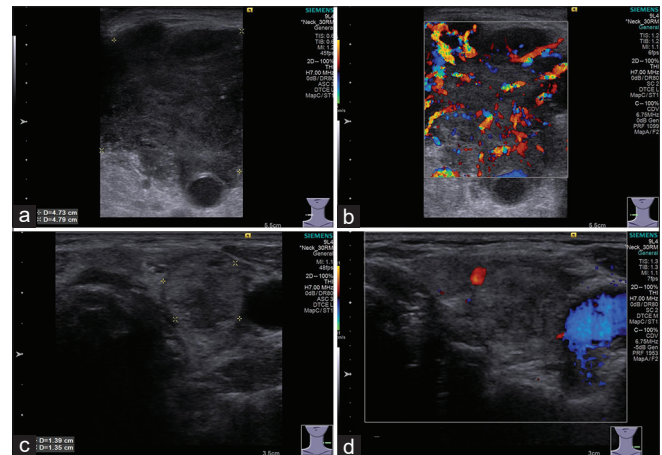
(a) Transverse sonogram of the neck reveals a heterogeneous hypoechoic mass with an irregular border in the right lobe of thyroid gland. Note posterior acoustic enhancement under the nodule. (b) The color Doppler ultrasound shows abundant twisted blood flow signals in the tumor. (c and d) Note a nodular goiter in the left lobe of thyroid gland with minimal blood flow signals
